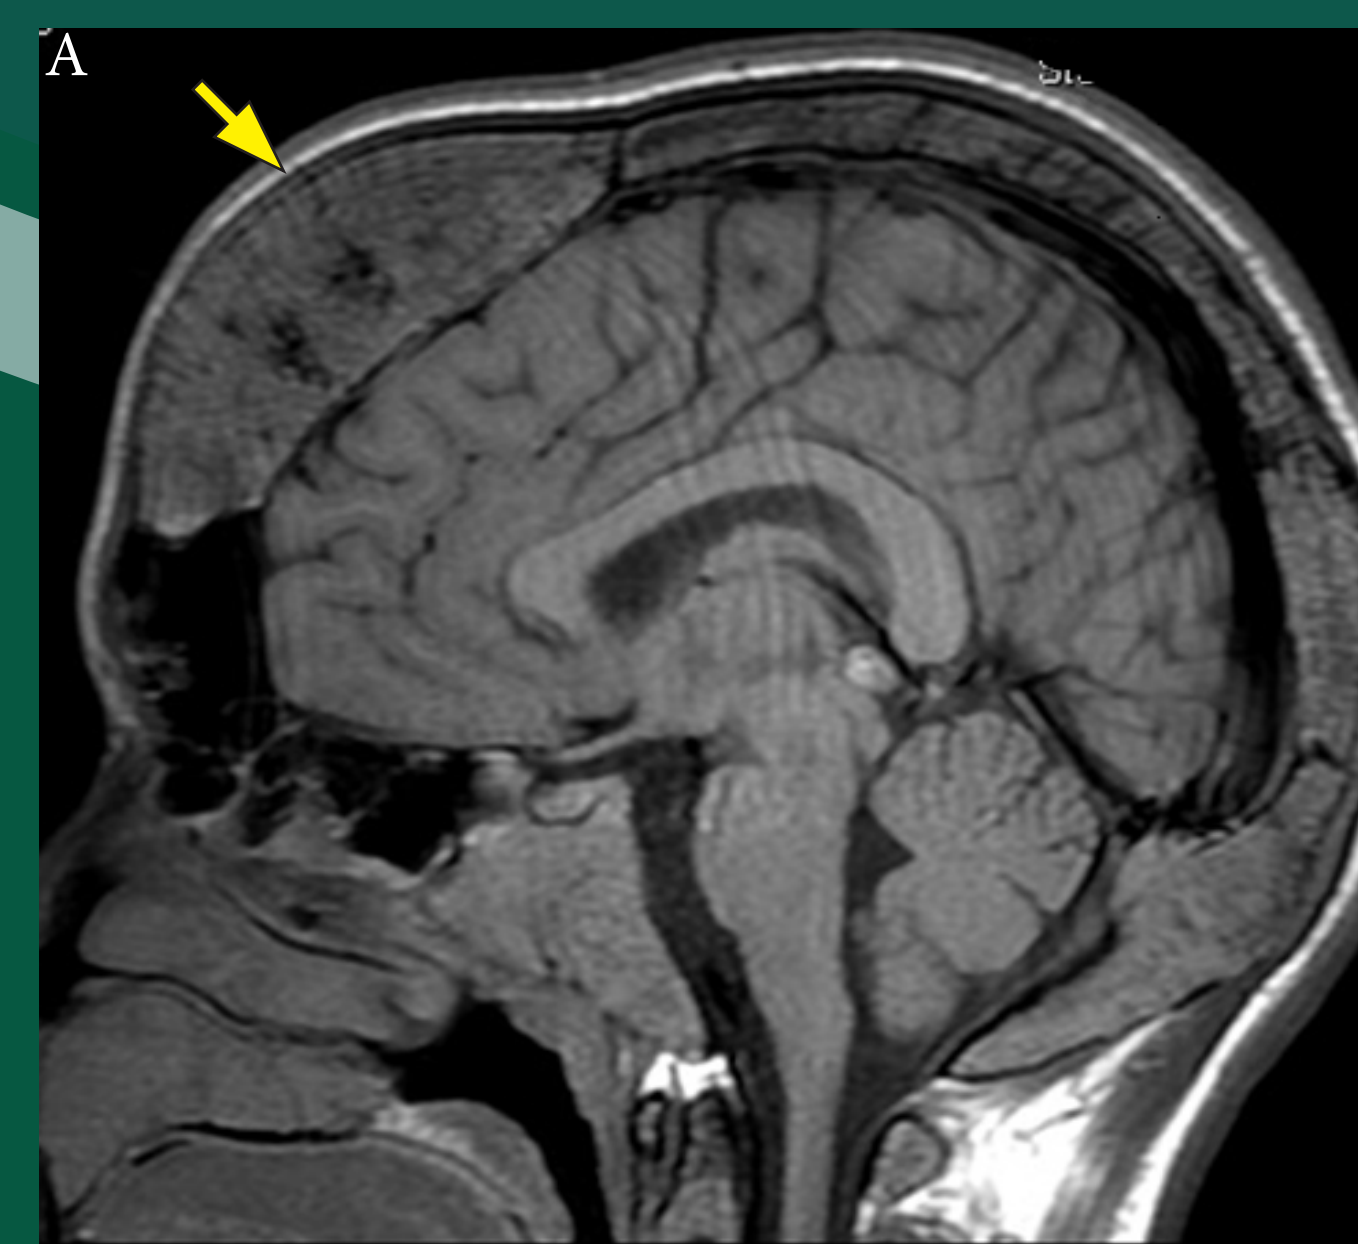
Magnetic Resonance Imaging (MRI) of the brain. (A) sagittal, (B-C) coronal, and (D-G) axial projections demonstrating marked diffuse expansion of diploic space and bone marrow of the calvarium, mastoid processes, and bilateral maxillary bones. Findings reflect EMH.
